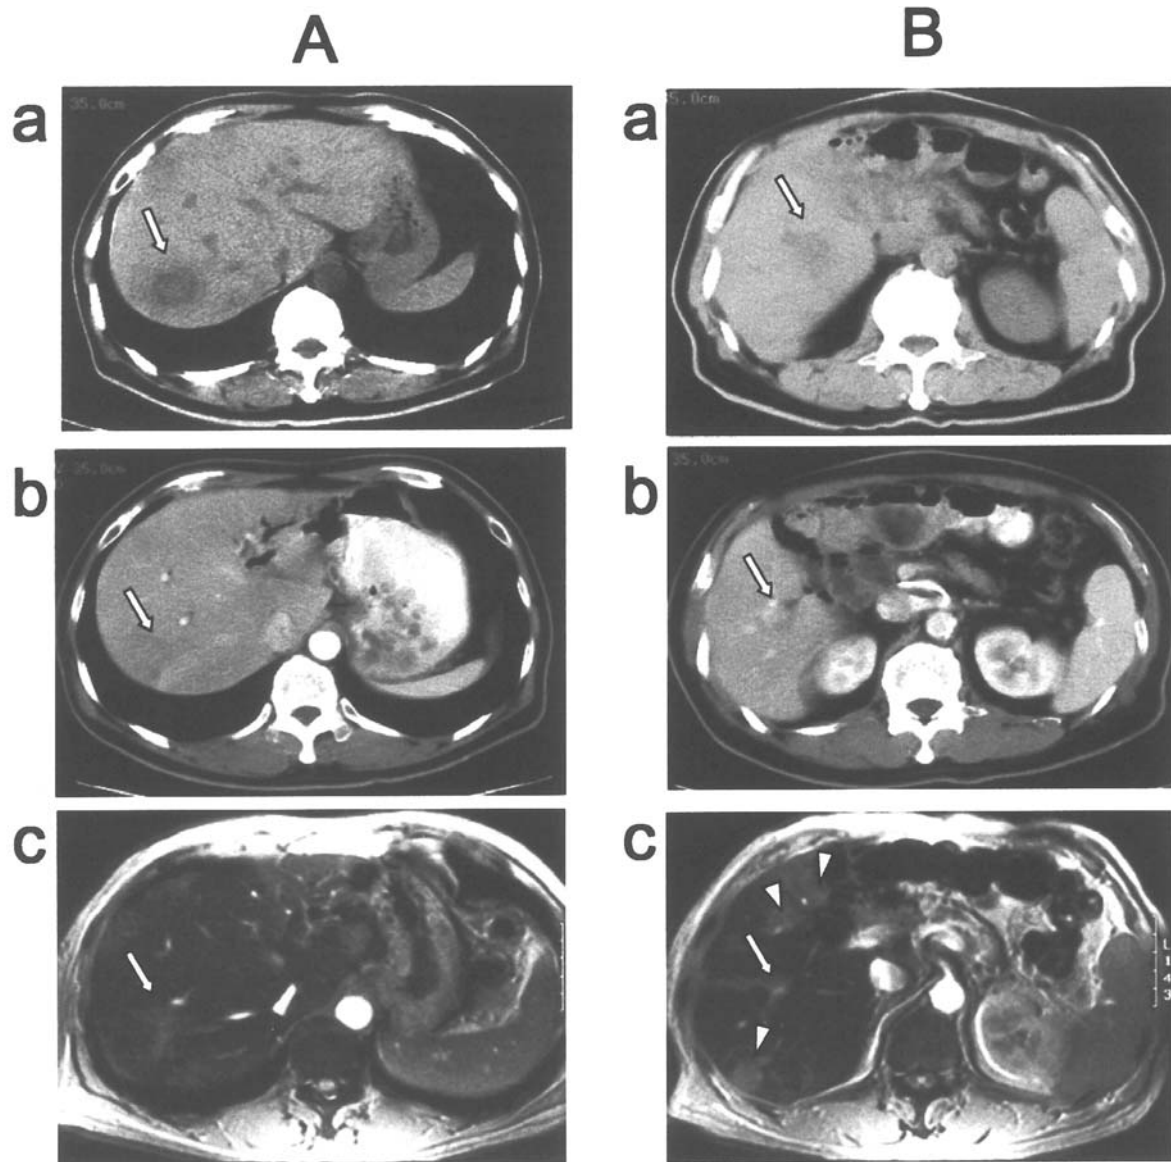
Serial changes in radiological findings of the two major liver metastases (arrows) in patient 3. A and B demonstrate metastatic tumours located at the segments VII and V/VI of the liver, respectively. A-a and B-a: CT findings before the start of HAI, indicating the tumours as low density areas. A-b and B-b: CT findings at 8 months after the start of HAI. A-b shows a vague low density area without contrast enhancement at a tumour site, suggesting no or minimal viability of the mass. B-b demonstrates an enhanced area within the shrinking tumour, suggesting its remaining viability. A-c and B-c: MRI findings at 18 months after the start of HAI, showing asterisk-shaped scars without viable tumours. Note the chemotherapy-induced fatty deposits in some areas of the liver (B-c, arrowheads).
